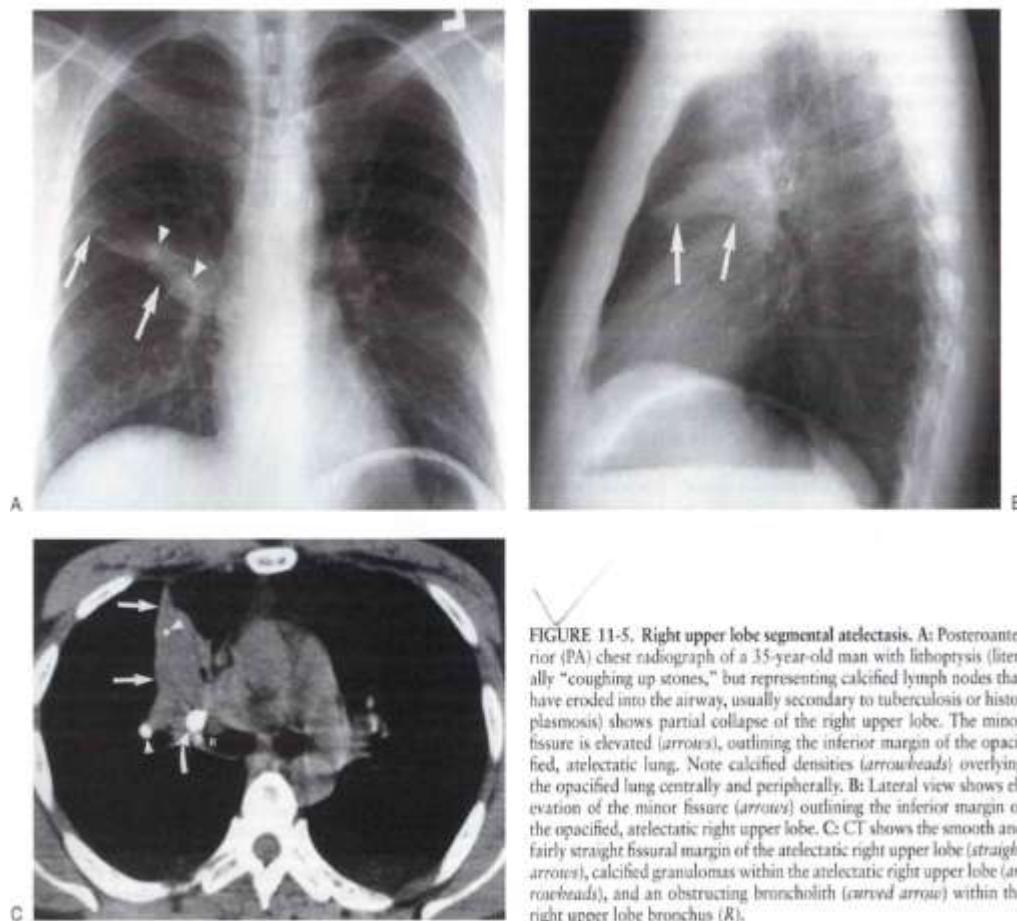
Right upper lobe segmental atelectasis. A: Posteroanterior (PA) chest radiograph of a 35-year-old man with lithoptysis (literally "coughing up stones," but representing calcified lymph nodes that have eroded into the airway, usually secondary to tuberculosis or histoplasmosis) shows partial collapse of the right upper lobe. The minor fissure is elevated (arrows), outlining the inferior margin of the opacified, atelectatic lung. Note calcified densities (arrowheads) overlying the opacified lung centrally and peripherally. B: Lateral view shows elevation of the minor fissure (arrows) outlining the inferior margin of the opacified, atelectatic right upper lobe. C: CT shows the smooth and fairly straight fissural margin of the atelectatic right upper lobe (straight arrows), calcified granulomas within the atelectatic right upper lobe (arrowheads), and an obstructing broncholith (curved arrow) within the right upper lobe bronchus (R).
